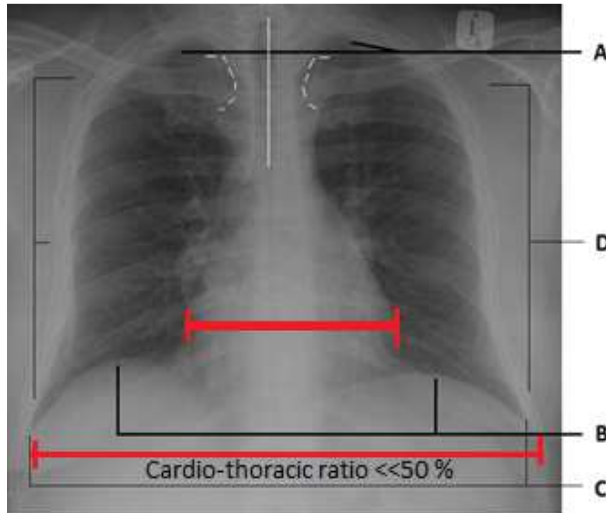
PA Chest radiograph
